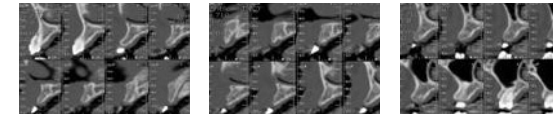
Maxillary dental CT taking after surgical splint inserted.
